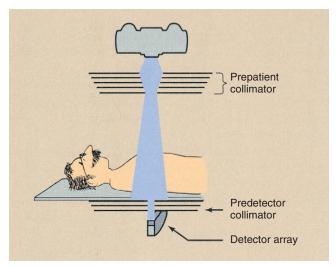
Multislice helical computed tomography imaging systems incorporate both a prepatient collimator and a predetector collimator.
